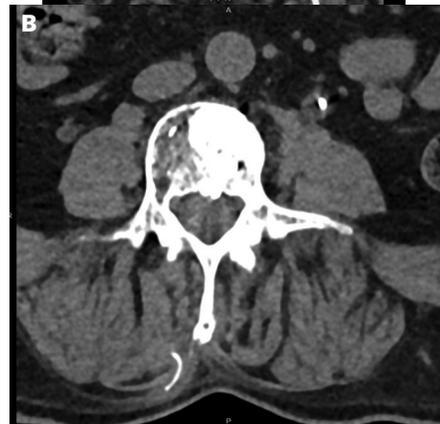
A) Sagittal computed tomography image of lumbar spine with retained PNS lead and soft tissue mass. B) Axial computed tomography image of lumbar spine with retained PNS lead.
